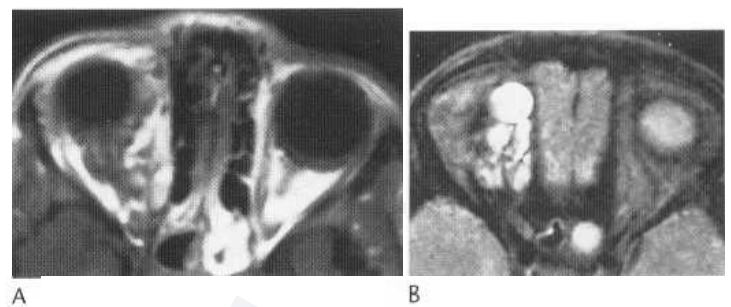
Lymphangioma. Axial T₁-weighted (A) and T₂-weighted (B) MR images demonstrate mild right proptosis due to complex, multi-lobulated, cystic, extra-axial lesion in the superomedial aspect of the right orbit.
